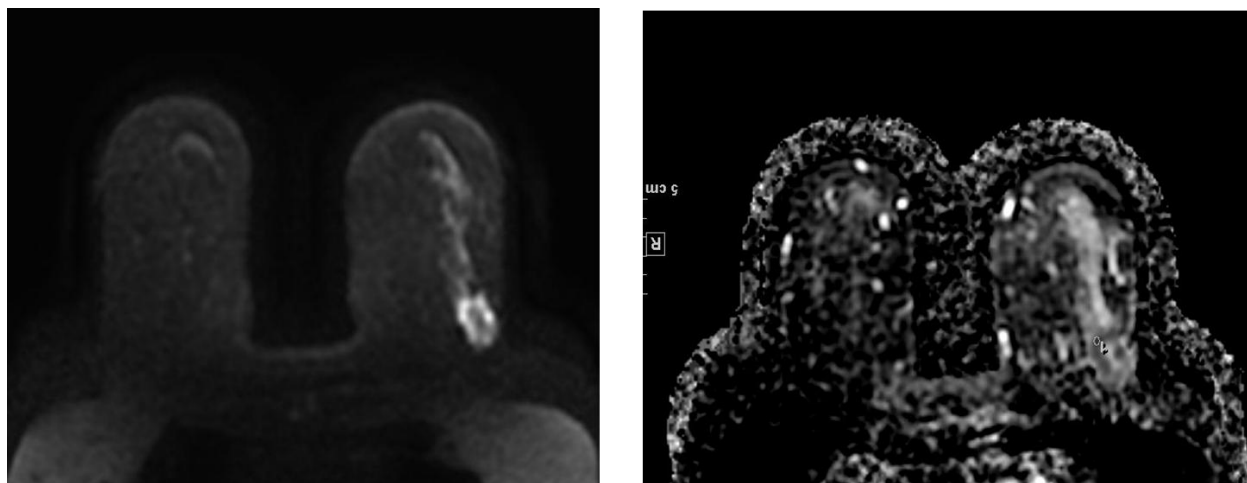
DWI demonstrate peripheral hyperintense areas in the lesion and corresponding areas in ADC maps shows hypointense areas. ROI placed in the hypointense area in ADC maps shows the Apparent Diffusion Coefficient of the lesion.
